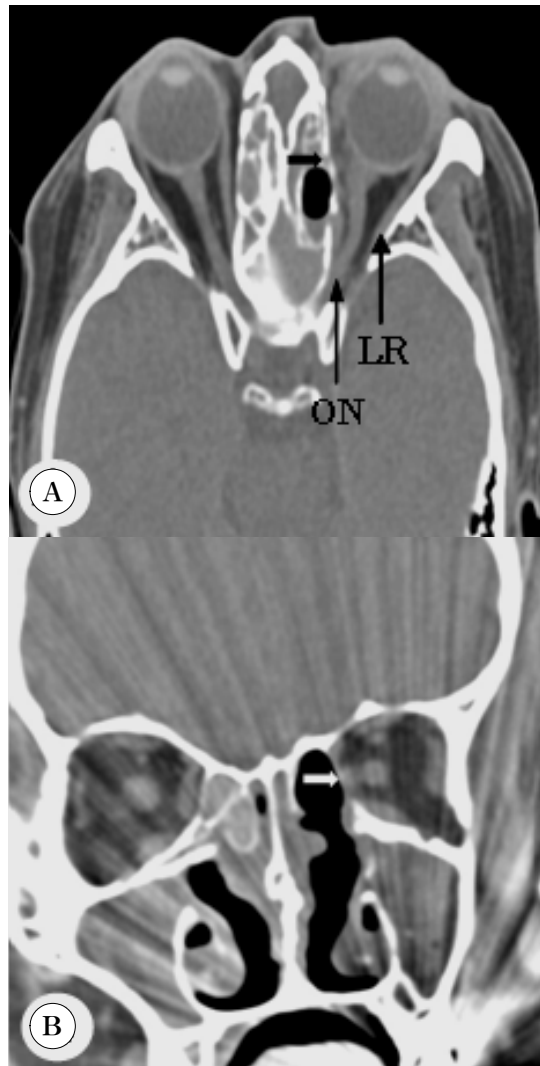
The axial (A) and coronal (B) view of orbital CT scans. These CT scans show the left side medial orbital wall injury and the ruptured medial rectus muscle (black and white arrow). ON: optic nerve, LR: lateral rectus muscle.
